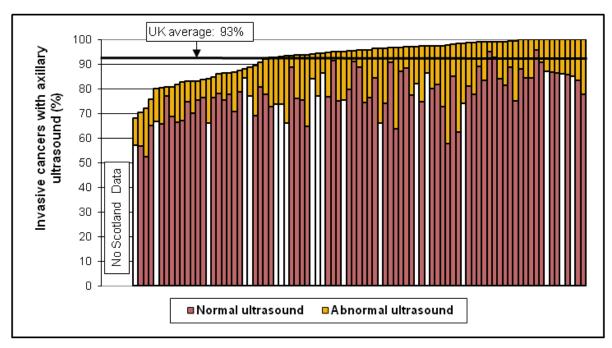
Variation between screening units in the proportion of invasive cancers with abnormal and normal axillary ultrasound results
